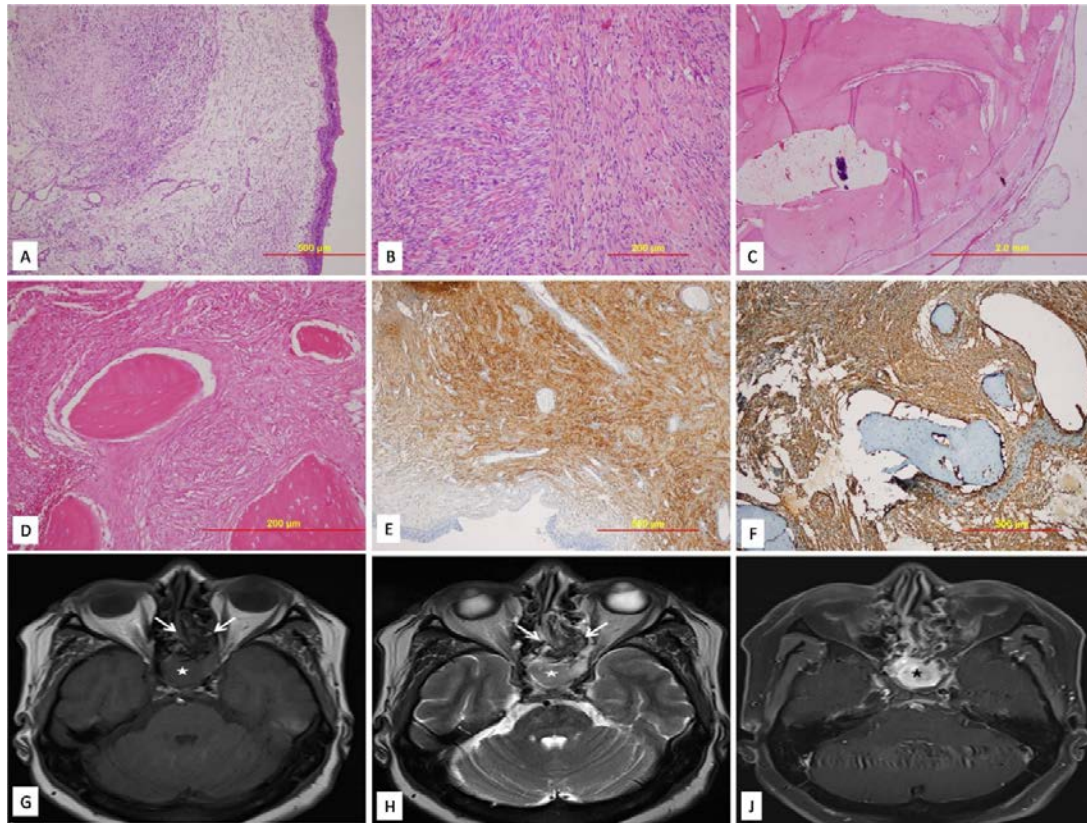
A (HEX100) Spindle cell neoplasm with vaguely hypocellular and hypercellular arrangement under the mucosal respiratory epithelium. B (HEX200) Some areas are cellular (left side), some areas are fibrotic (right side). C (HEX40) Dense mature bone formed neoplasm that was sharply demarcated from mucosal respiratory epithelium. D (HEX200) Spindle cells are in interosseous areas. E, F (S-100X100) Spindle cells for S-100 positive in peripheral and interosseous stroma. G, H, J (CT figures) Axial pre-contrast T1 and T2-weighted images (G, H) show a mass with a solid component isointense to the cortex of the brain (white stars) and a hypointense osseous component (arrows). Post-contrast axial T1-weighted images (J) show enhancing solid component and extension of the mass to anterior cranial fossa (black stars).
